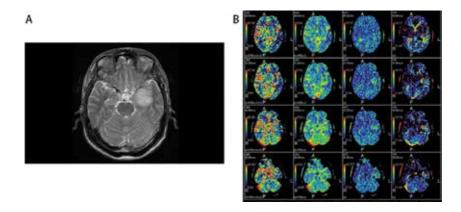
(A) T2-weighed magnetic resonance image of a 59-year-old male who presented to our hospital because of dizziness and nausea. An edematous region of the temporal lobe is apparent, suggesting the presence of limbic encephalitis. (B) A CT perfusion imaging of the same patient. From left to the right, CBF, CBV, MTT, and TTP are visualized. The corresponding region where limbic encephalitis is suspected, an apparent increase of CBV and TTP is observed. CBF remained intact and a slight increase of MTT is also observed.
